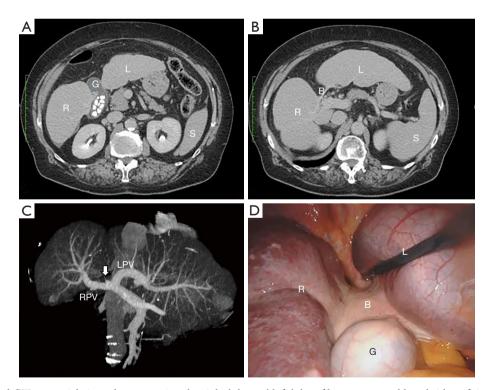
Abdominal CT-scan axial views demonstrating the right lobe and left lobe of liver connected by a bridge of tissue (A,B); abdominal CT-scan coronal view demonstrating the portal vein trifurcation with the sketch of the portal branch for hypoplastic segment IV (arrow), the RPV and LPV (C); intraoperative views of the bipartite liver with the right lobe and left lobe connected by a bridge of tissue (D). R, right liver lobe; G, gallbladder; L, left liver lobe; S, spleen; B, bridge connecting liver lobes; RPV, right portal vein; LPV, left portal vein.
